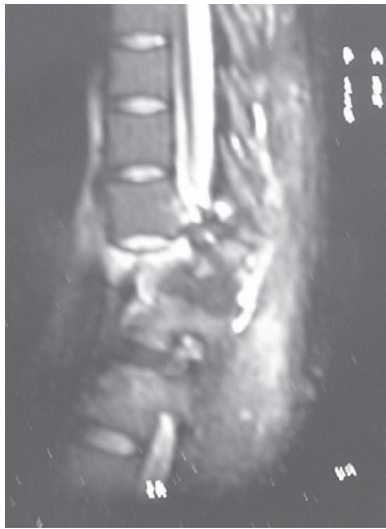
MRI showing fracture dislocation at D12-LV1
